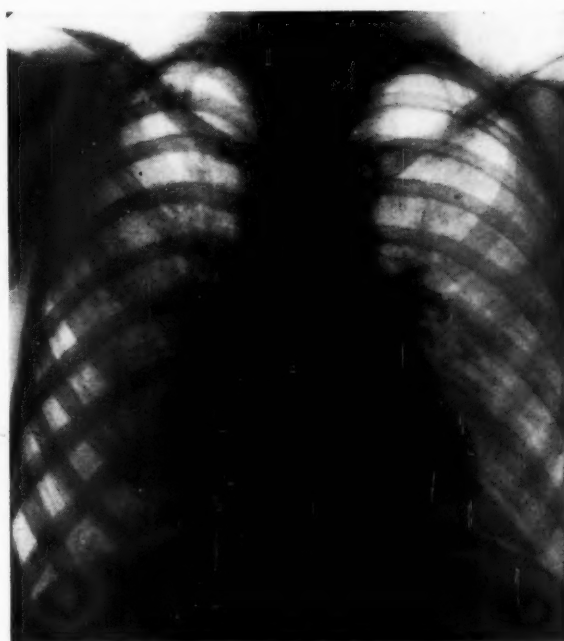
Radiograph of U. on October 27, 1952.
